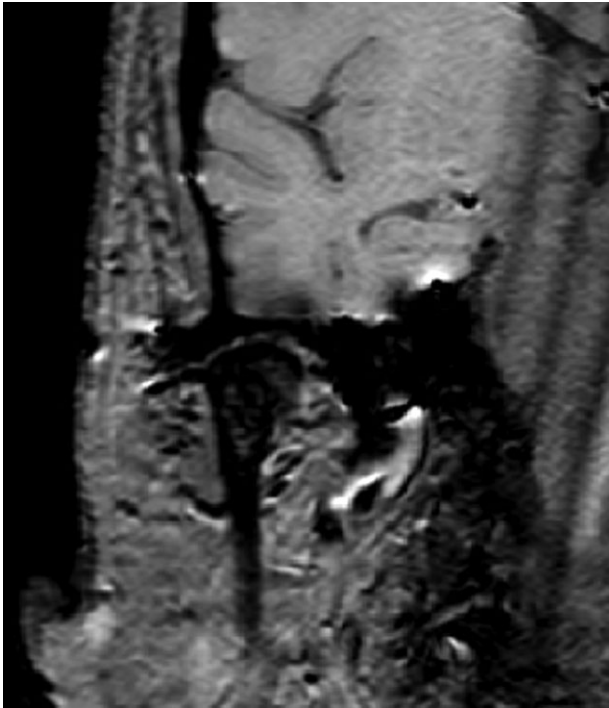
MRI revealing the synovial proliferation in the right TMJ with punctate calcifications, displacing the articular disc to a medial position. MRI, magnetic resonance imaging; TMJ, temporomandibular joint.
